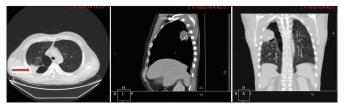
Chest computed tomography showed ill-defined soft tissue masses in the right upper lobe (S2 and S3 region) 5,7 cm in diameter with enlarged lymph node 1,6cm in diameter
